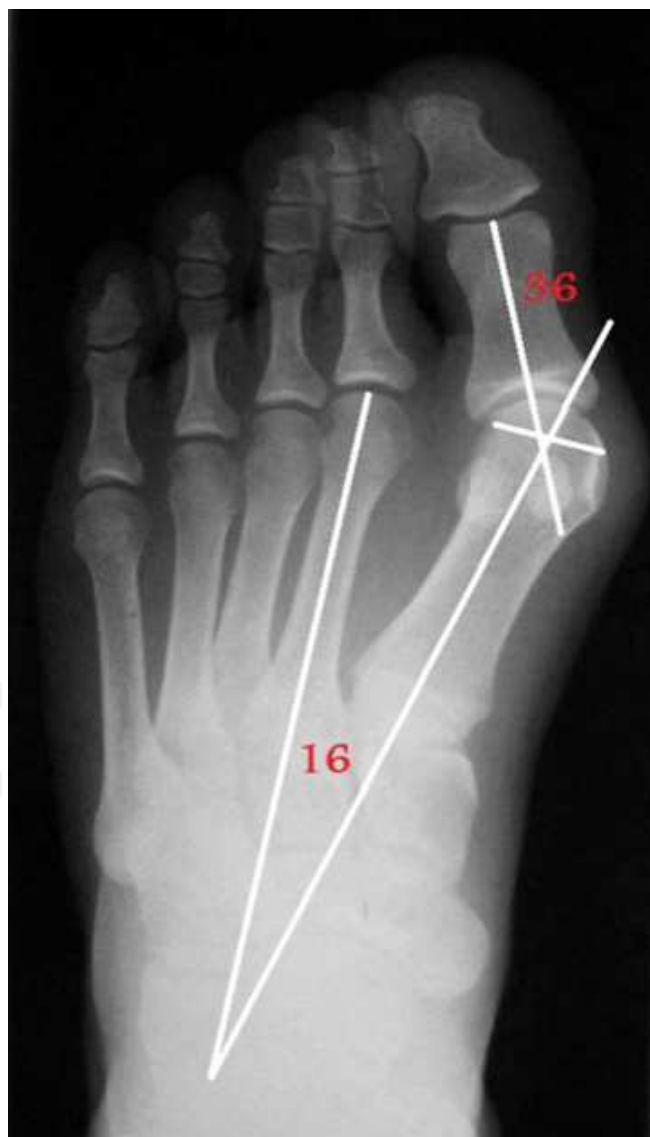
A-P standing radiograph. Measurement of HVA and first IMA.
